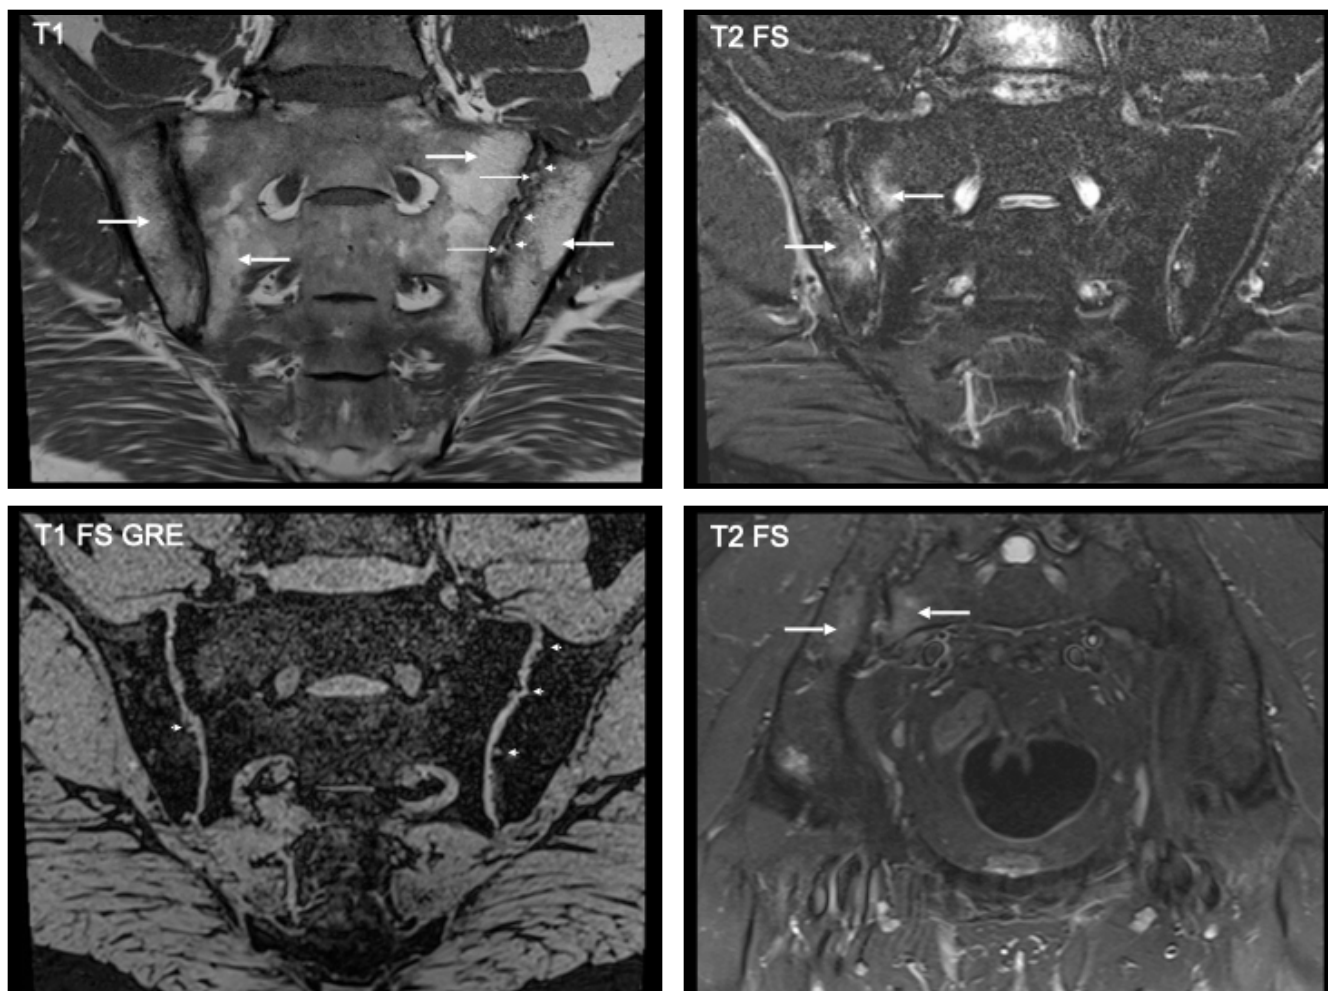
Typical patterns of MRI changes in the sacroiliac joints in axial spondyloarthritis; *courtesy of Denis Poddubnyy, MD, PhD, MSc (Epi).*
